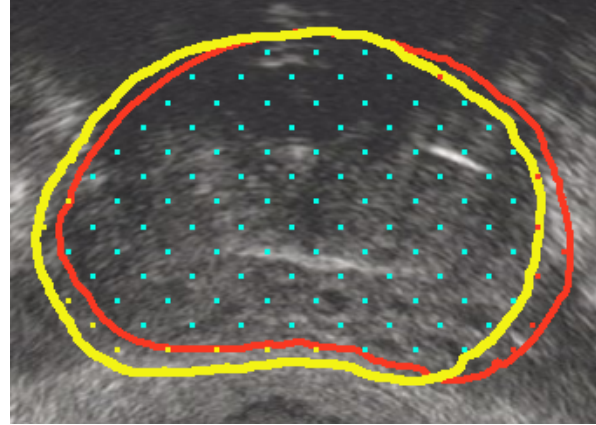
Two delineations of a prostatic target volume based on a transversal ultrasound imaging scan. Both delineations yield a different set of calculation points residing in the structure: the blue points reside in both structures, the yellow and red points only in the yellow and red delineation, respectively.
